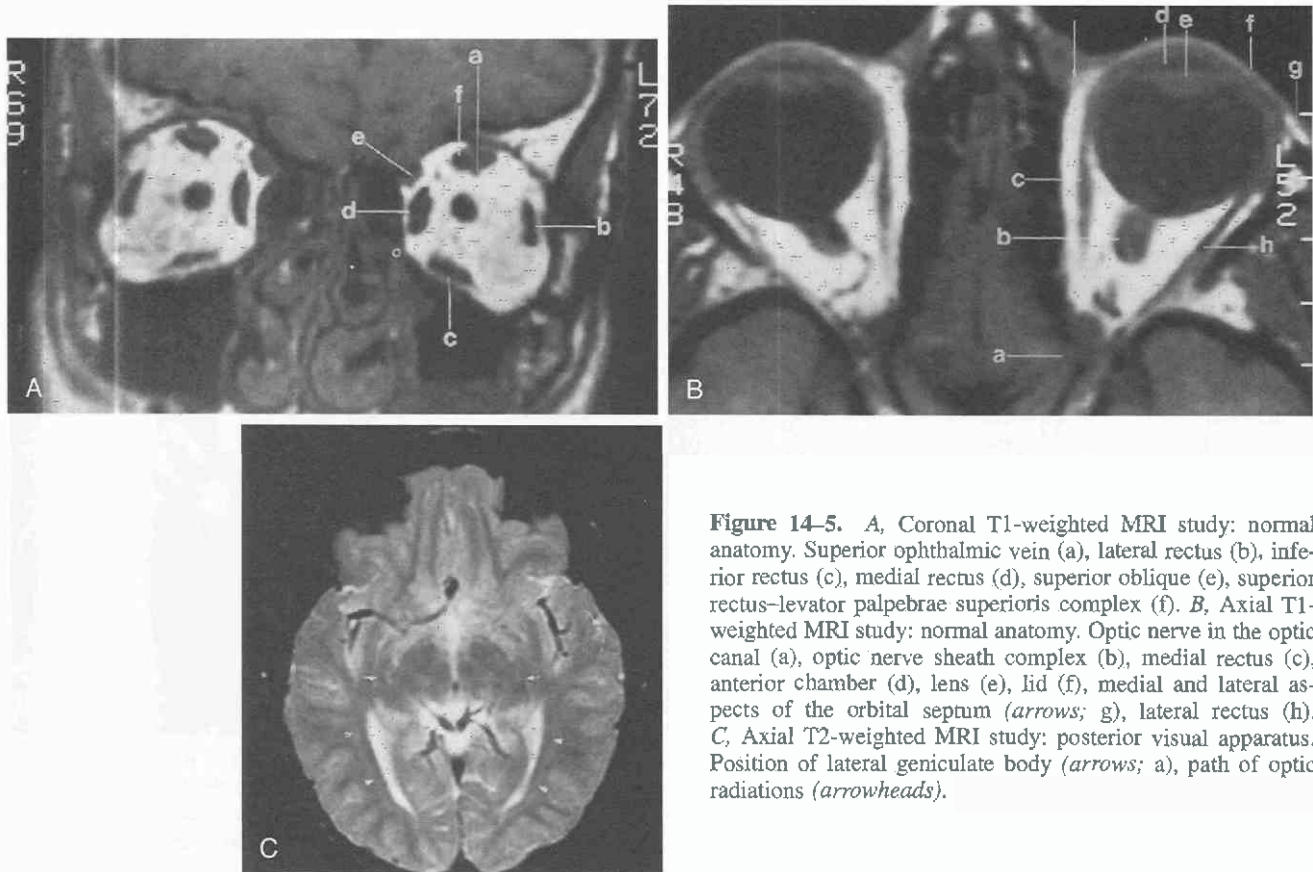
A, Coronal T1-weighted MRI study: normal anatomy. Superior orbital vein (a), lateral rectus (b), inferior rectus (c), medial rectus (d), superior oblique (e), superior rectus–levator palpebrae superioris complex (f). B, Axial T1-weighted MRI study: normal anatomy. Optic nerve in the optic canal (a), optic nerve sheath complex (b), medial rectus (c), anterior chamber (d), lens (e), lid (f), medial and lateral aspects of the orbital septum (arrows; g), lateral rectus (h). C, Axial T2-weighted MRI study: posterior visual apparatus. Position of lateral geniculate body (arrows; a), path of optic radiations (arrowheads).
